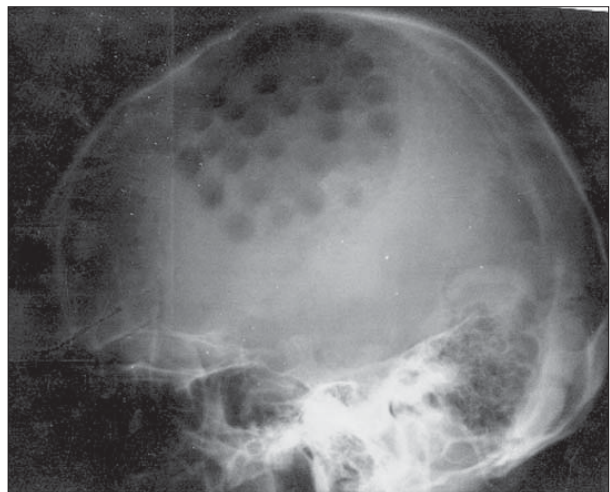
X-ray film of skull after milling of multiple apertures
